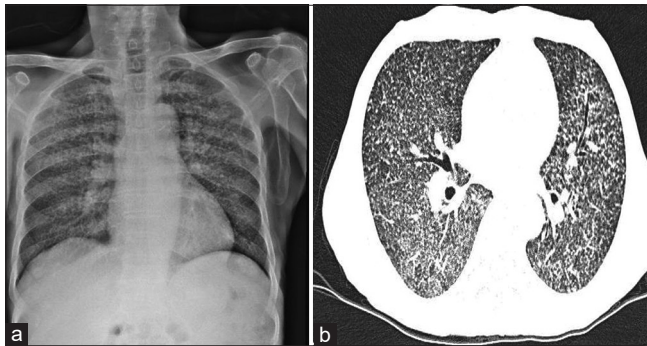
Chest X-ray showing military mottling (a). Contrast-enhanced computed tomography of the thorax shows extensive lung nodules in the bilateral lung fields suggesting military tuberculosis (b)
